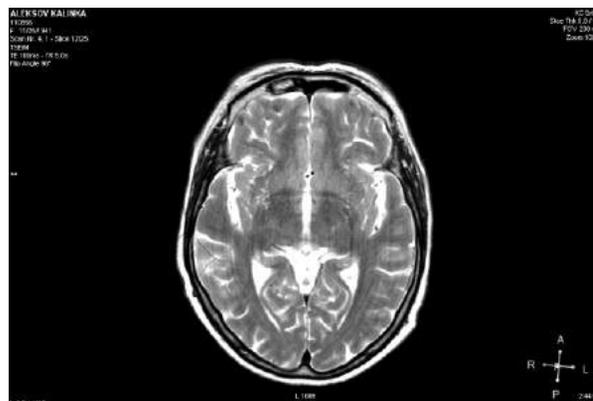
MRI - supratentorial multiple microangiopathic lesions, and cortical brain reductive changes
